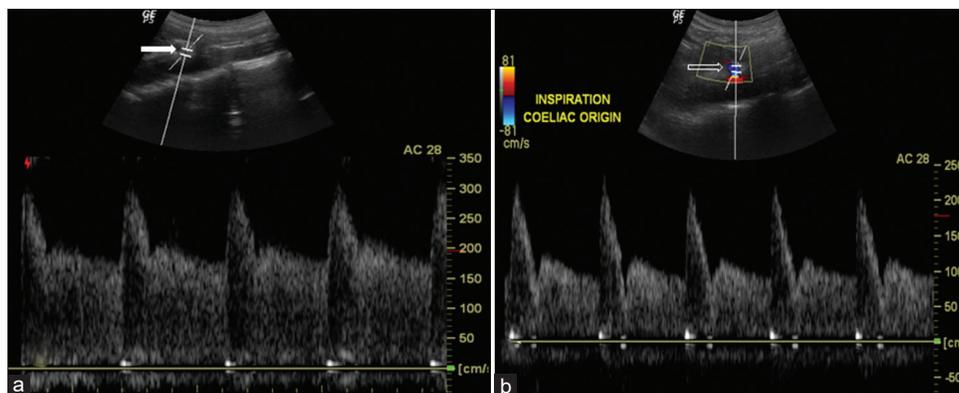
Spectral Doppler images with Doppler gate at the origin of celiac trunk in expiration (a) and in inspiration (b) show raised peak systolic velocity in celiac trunk which partially reduces on inspiration.
